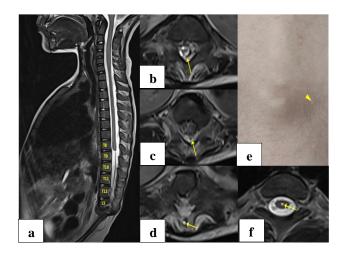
(a) Sagittal T2 WI MRI of whole spine reveals high blind ending truncated conus medullaris at the level of T8 vertebral body, with a filum (measuring 1.2 mm) extending caudally and attaching to the anterior dural sac at the lower margin of T12 vertebral body; (b-d) axial T2WI MRI images of spine, showing deeper attachment of CSDST to the posterior thecal sac (arrow), its intraspinal course (arrow) and interspinous course (arrow) respectively; (e) gross image of the back of patient showing a skin patch in the right para-midline (arrowhead); and (f) axial T2 WI MRI image showing a central intramedullary syringohydromyelia (arrow).
